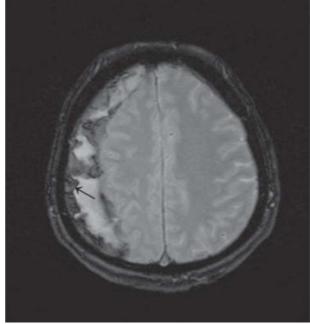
Gradient ECHO MRI shows mixed signal of chronic blood products in suspected area. (arrow)
